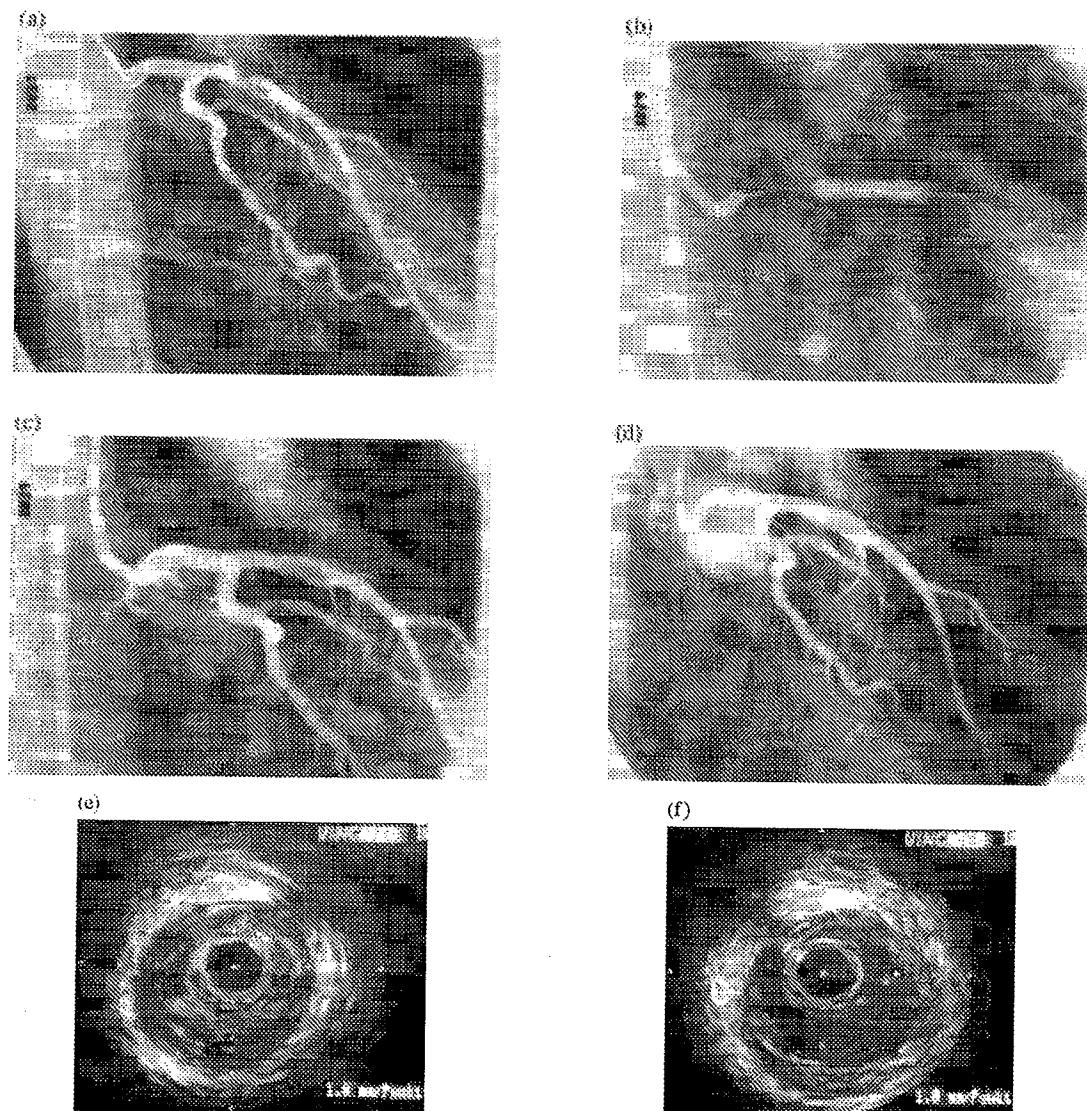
(a) Coronary angiogram from a patient with a proximal left anterior descending artery stenosis before angioplasty. (b) After a 0.014 inch guidewire has been placed in the periphery of the target vessel, a 5.0 mm balloon (Schneider, Bypass Speedy) is positioned in the stenotic vessel segment and inflated with a pressure of 7 atmospheres over a time period of 120 s. (c) The result immediately post-PTCA shows a 20% residual stenosis with no visible dissection. (d) Control angiography 1 year following the intervention shows an excellent long-term result. (e) In the pre-interventional intravascular ultrasound images, the catheter was 'stuffed' into the lesion; the lesion contained almost exclusively 'soft' plaque elements (the plaque elements were less dense than the reference adventitia). External elastic membrane diameter of this vessel was 5.4 mm, external elastic membrane cross-sectional area was 22.2 mm². (f) The post-interventional intravascular ultrasound image shows a cross-sectional area at the lumen site of 13 mm² indicating a sufficient luminal gain achieved by balloon angioplasty (f).
